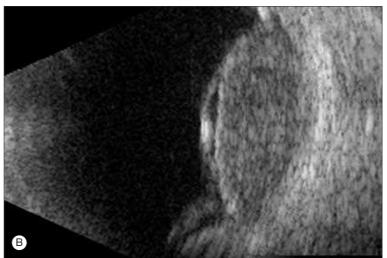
Choroidal Melanoma Exhibiting Typical Smoothly Nodular Dome Shape. (A) Clinical appearance of tumor. (B) Corresponding B-scan ultrasonographic image showing bluntly biconvex cross-sectional shape and relatively low internal sonoreflectivity of tumor.
